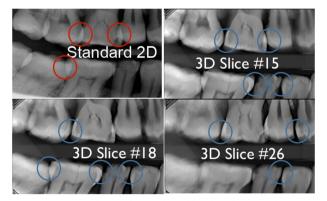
Comparison of standard bitewing image with s-IOT reconstructions showing contacts free of superimposition. 2D, two-dimensional; 3D, three-dimensional.
